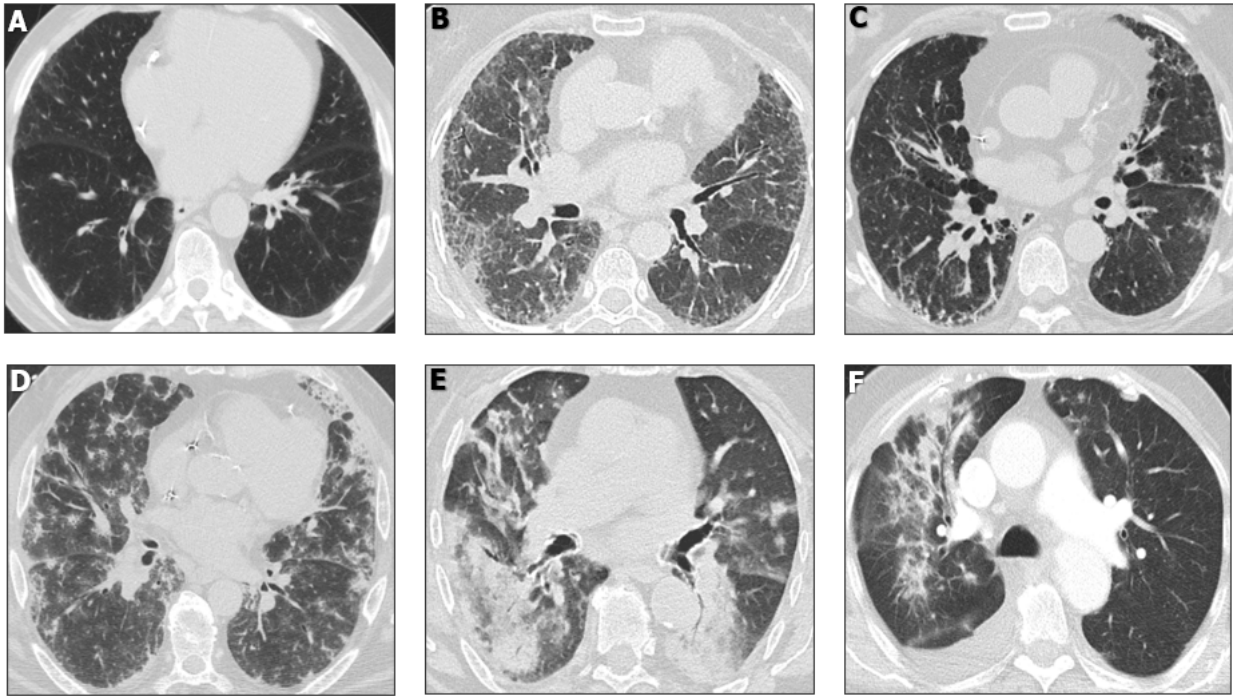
Representative cuts of the chest CT scans of each case presented, at the time of AIPT diagnosis. A) Case 1. Mild, reticular, and ground glass opacities and interlobular septal thickening with lower lobe predominance. B) Case 2. Diffuse, bilateral ground glass opacities, interlobular septal thickening and developing peripheral airspace opacity in the right lower lobe. C) Case 3. Reticular opacities, minimal ground-glass opacities, bronchioloectasis and focal honeycombing. D) Case 4. Reticular-nodular pattern, involving all lobes, with diffuse distribution, and ground glass opacities in the background. E) Case 5. Confluent airspace opacities and surrounding ground glass opacities with diffuse distribution, but worse in the lower lobes. F) Case 6. Developing airspace opacities prevalently in the right lung, surrounding ground glass opacities, interlobular septal thickening and ipsilateral pleural effusion.
